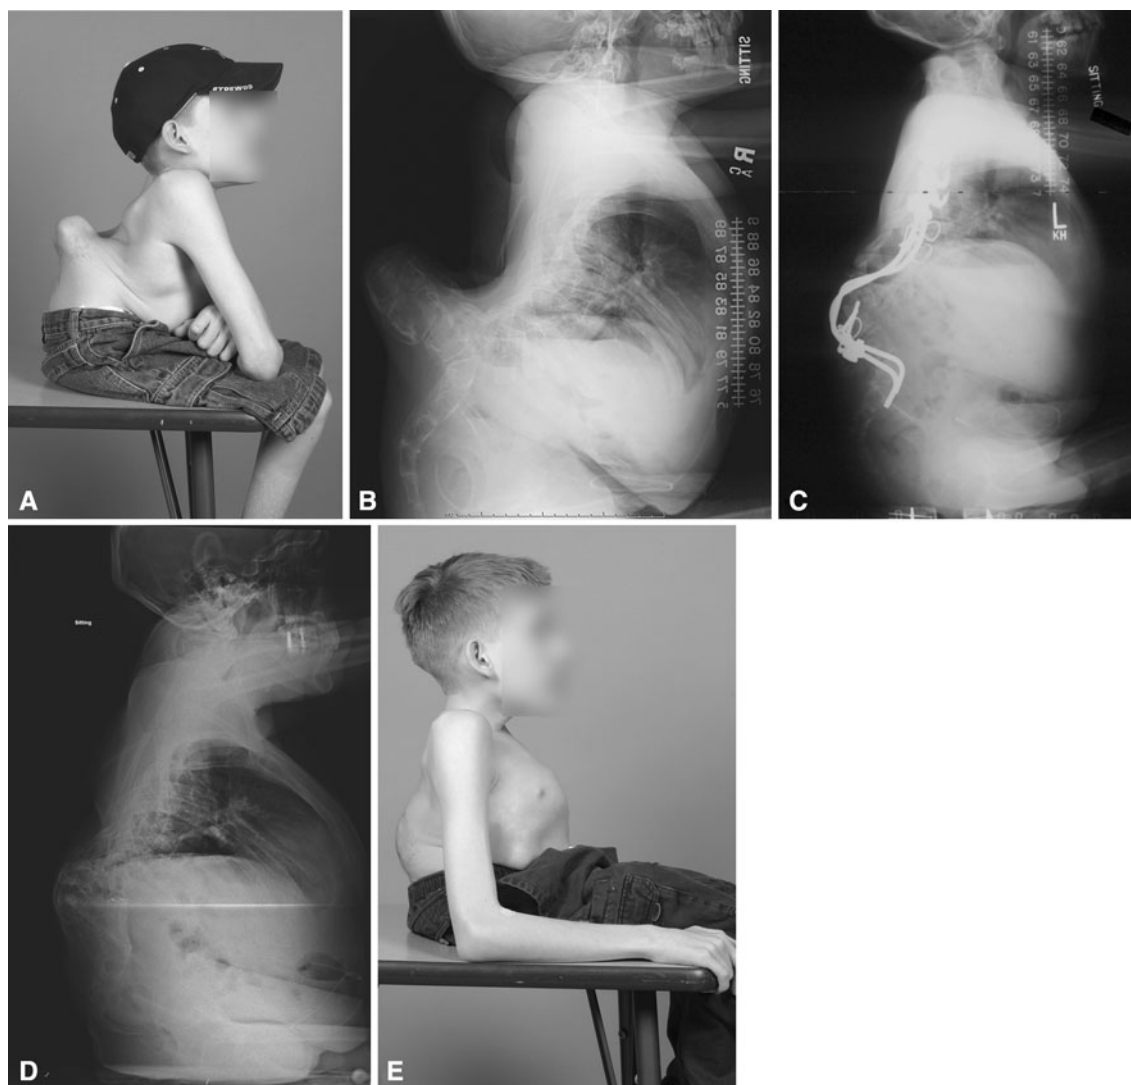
A–E (A) A photograph and (B) a sitting sagittal radiograph show the preoperative clinical and radiographic appearance of a patient with thoracic-level myelomeningocele and severe rigid hyperkyphosis. (C) A postoperative sitting sagittal radiograph shows the patient after kyphectomy with segmental proximal spinal fixation and distal sacral fixation. The patient developed an early deep
